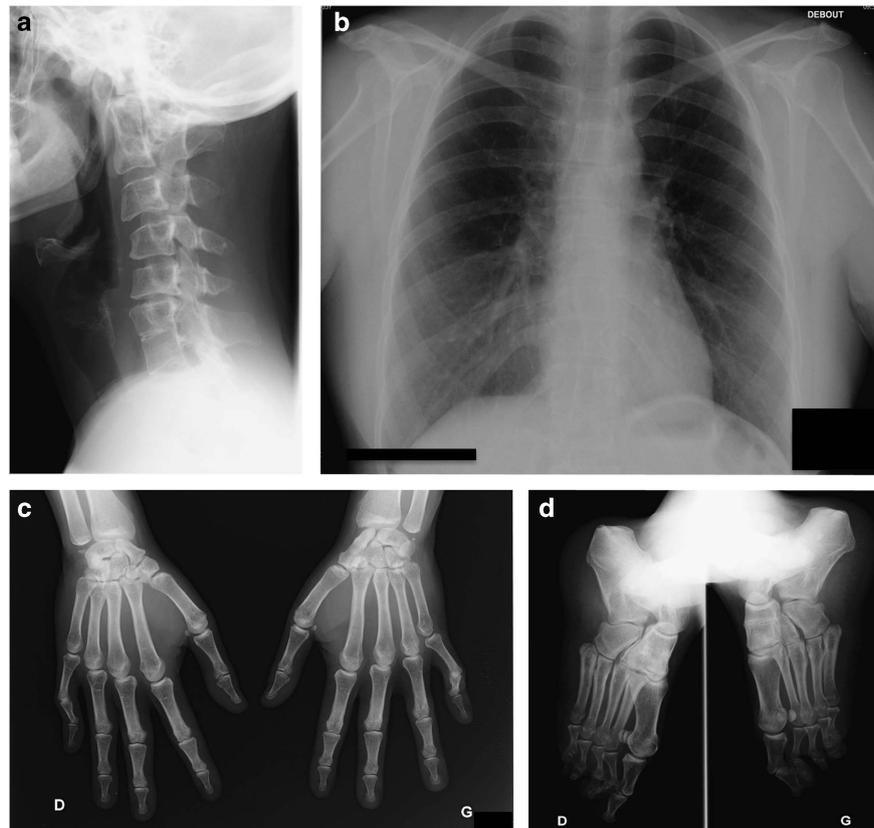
X-ray imaging of patient 2-I.2. (a) Lateral X-ray of cervical spine showing C1–C2 and C6–C7 anterior fusion associated with C1–C3 and C5–C7 posterior fusion. (b) AP pulmonary X-ray showing narrowing of intervertebral space T9–T10 and T11–T12, suggesting anterior fusions. Note the absence of spine or rib cage deformation. (c) AP X-rays of hands showing capitate–hamate and lunate–triquetrum coalitions of both hands associated with scaphoid–trapezium coalition of the left hand. (d) Oblique X-rays of feet showing a coalition between the navicular and the three cuneiforms of both feet.
